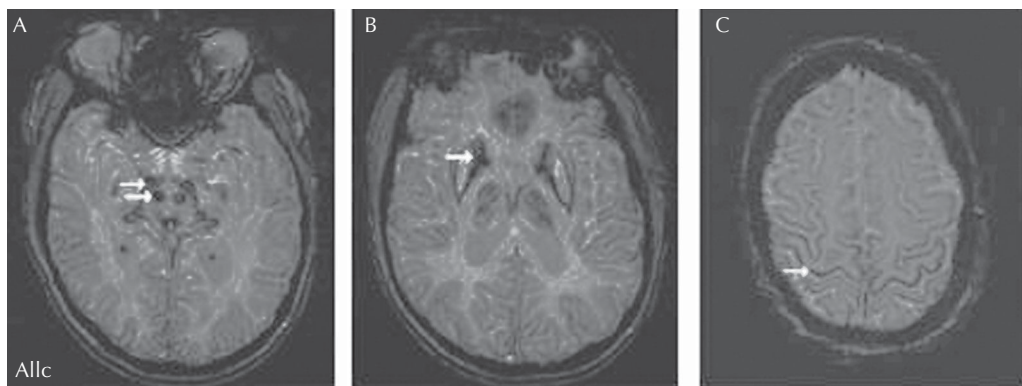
Characteristic imaging findings in disorders of brain iron accumulation. Susceptibility weighted MRI imaging showing iron in (A) red nucleus and substantia nigra, (B) globus pallidus, (C) motor cortex. (From Lehn A, Boyle R, Brown H, Airey C, Mellick G. Neuroferritinopathy. *Parkinsonism Rel Disord* 2012;18:909–915.)
